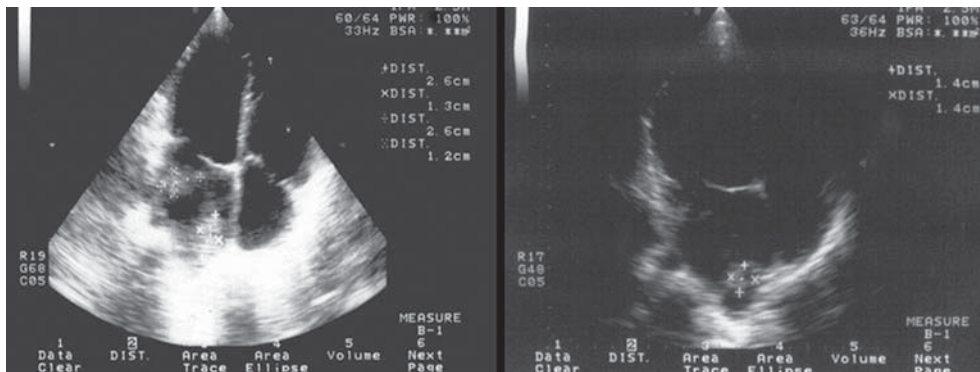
Echocardiographic evaluation of a cardiac thrombus before and after preoperative chemotherapy: absence of response.
